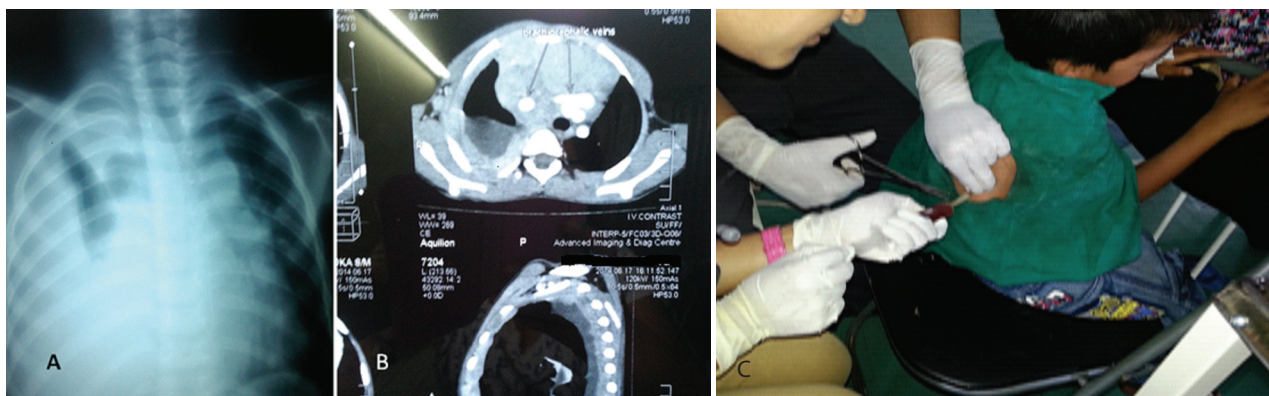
(A) Chest X-ray showing right pleural effusion. (B) Contrast CT scan showing mediastinal tumour in the anterior mediastinal space. (C) Haemorrhagic pleural tap.
